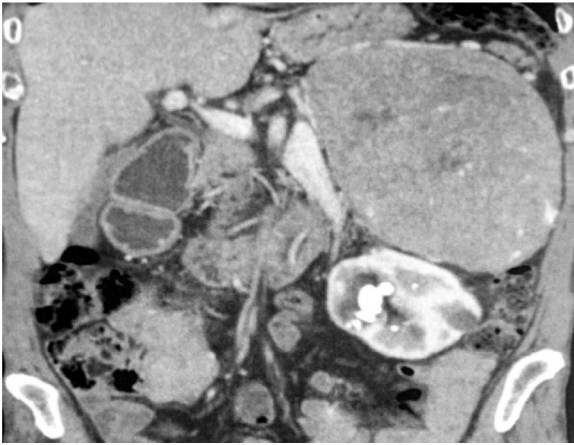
Contrast computed tomography showing a voluminous and heterogeneous supra-renal left mass.
